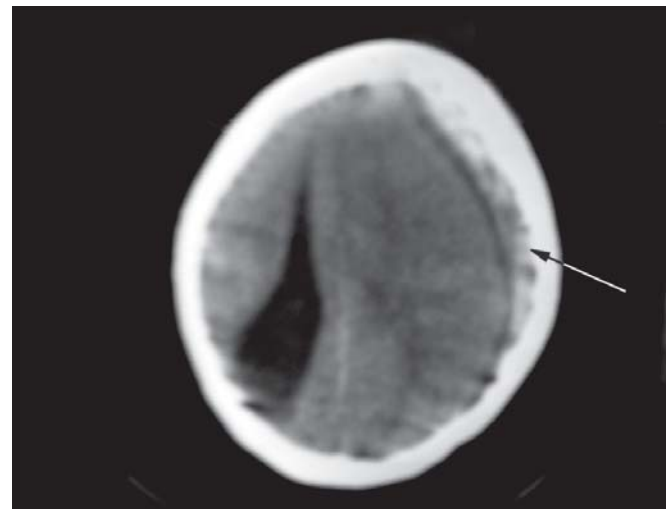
CT head showing subdural hematoma (concavo-convex) with midline shift
